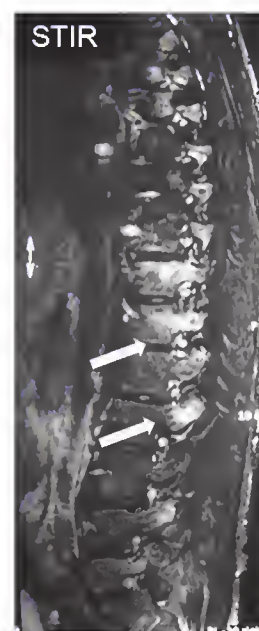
Magnetic resonance images showing (posterior) spondylitis and inflammation of the facet joints (arrows).
